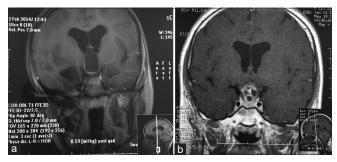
(a) T1W coronal MRI section with contrast showing a large cystic lesion occupying the third ventricle. (b) After transcortical endoscopic biopsy and fenestration of the cystic craniopharyngioma, the cyst collapsed and has been stable for 4 years with no symptoms and no treatment.
